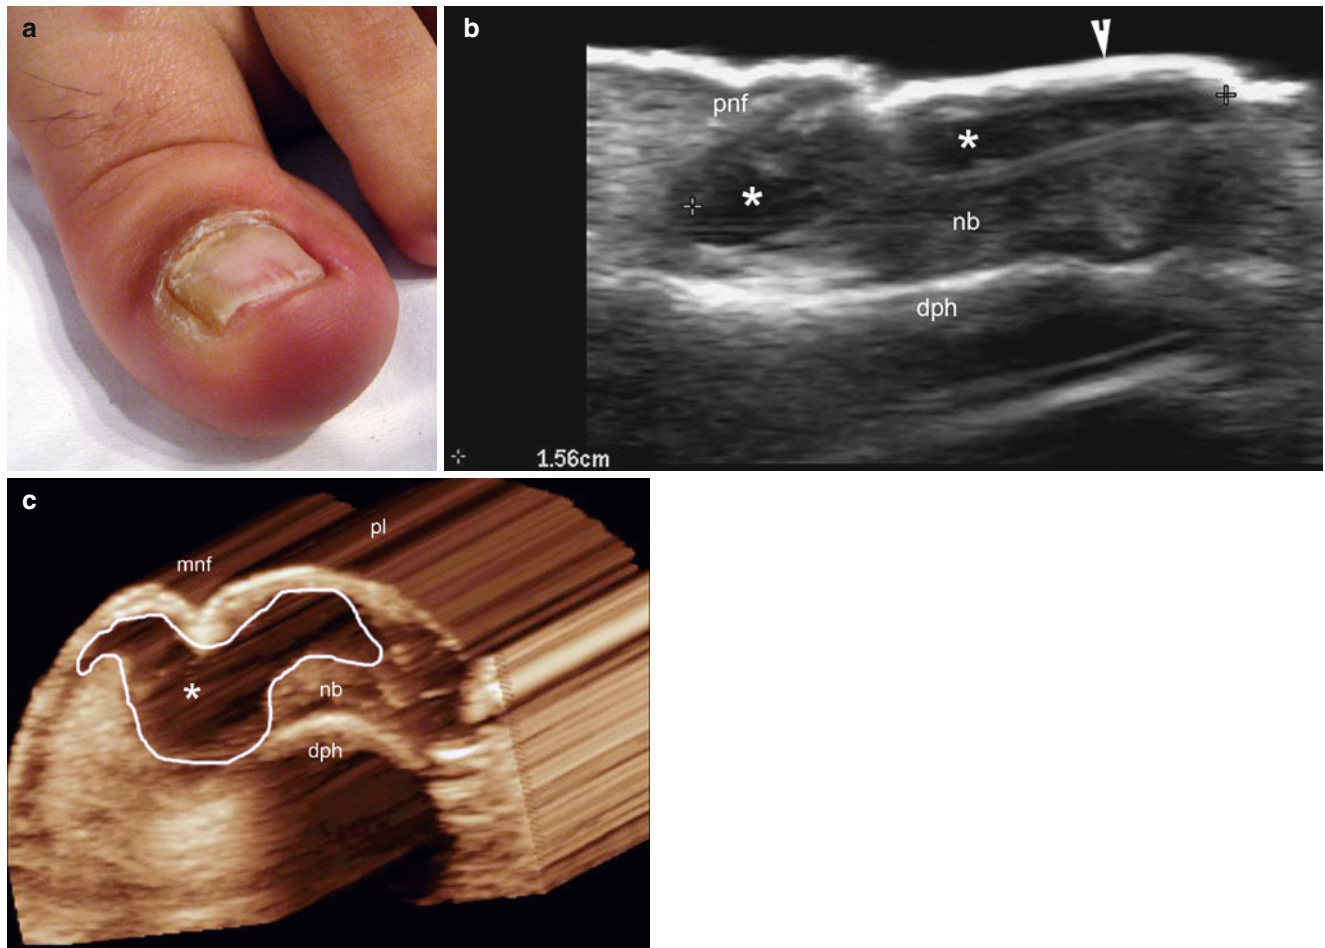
(a–c) Subungual and periungual abscess. (a) Clinical image shows dystrophic changes in the nail plate, erythema, and edema in the medial and lateral nail fold of the left hallux. (b) Grey scale ultrasound image (longitudinal view, left hallux) shows 1.56 cm long anechoic fluid collection (*) in the nail bed. Thickening of the nail bed
